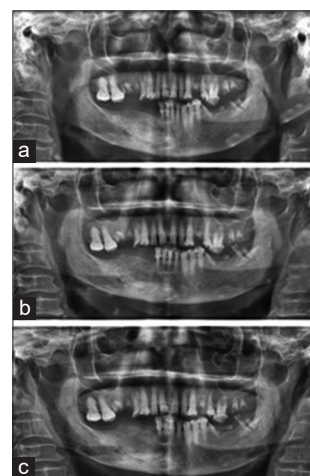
(a) Immediate postoperative radiograph radiopacity at grafted mandibular defect. (b) 3 months postoperative radiograph showing mild decrease in radiopacity due to graft resorption. (c) 6 months postoperative radiograph showing unremarkable and near-normal bone density comparable to that of adjacent healthy bone, suggestive of new bone formation
